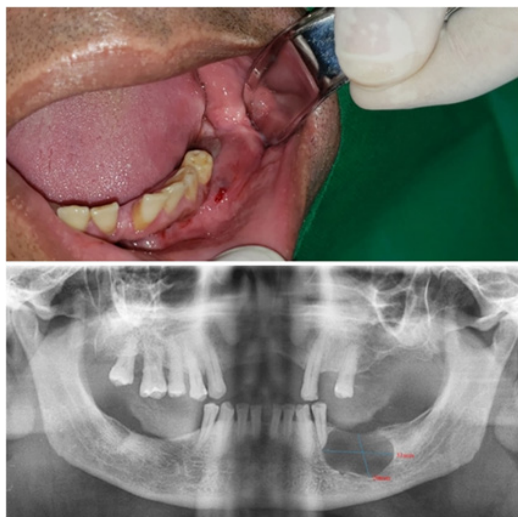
(A) Clinical appearance of the lesion region showing an increase in the volume in the alveolar mucosa of the bottom portion of the groove of the lower left first premolar and second molar. (B) Radiographic image showing a well-delimited, unilocular radiolucent area measuring about 30 x 20 mm close to the lower alveolar nerve canal and root of tooth 34, involving the left mandibular body.
